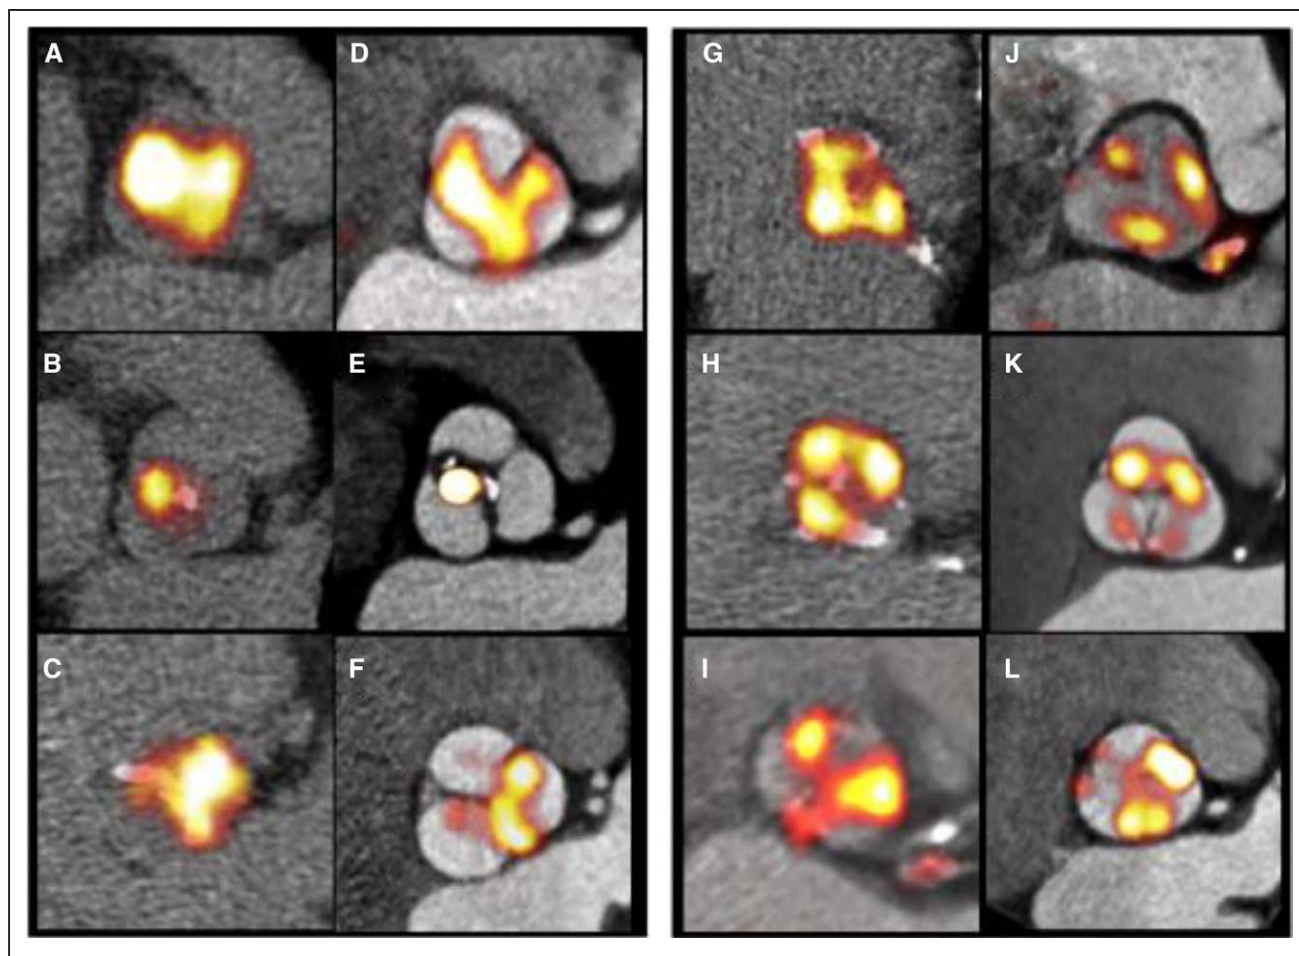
Improved localization of positron emission tomography (PET) signal within the aortic valve and its leaflets. Paired nongated, noncontrast PET/computed tomography (CT) scans (original approach A–C and G–I) and gated, contrast-enhanced PET/CT images (final approach D–E and J–L). Images demonstrate the typical distribution of the tracer uptake within the valve at sites of increased mechanical stress, that is, at the leaflet tips (left: A–F) and at the commissures (right: G–L).
